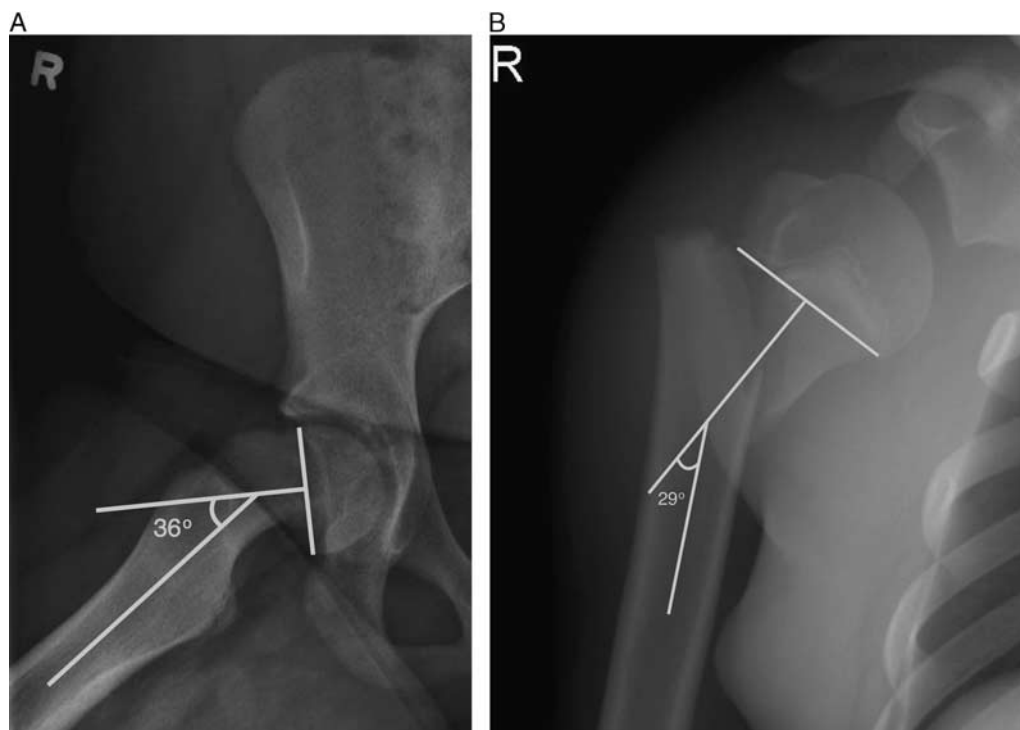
A, Right hip radiograph in a patient with slipped capital femoral epiphysis. The epiphyseal-shaft angle is measured on the frog-leg lateral pelvis radiograph. The angle is formed by a line perpendicular to the proximal femoral physis and the axis of the femoral shaft. B, Right shoulder radiograph in a patient with a proximal humerus physeal fracture. Our proposed measurement method for fracture angulation is similar to the measurement method for the epiphyseal-shaft angle in slipped capital femoral epiphysis. The angle is formed by a line perpendicular to the proximal humeral physis and the axis of the humeral shaft.
